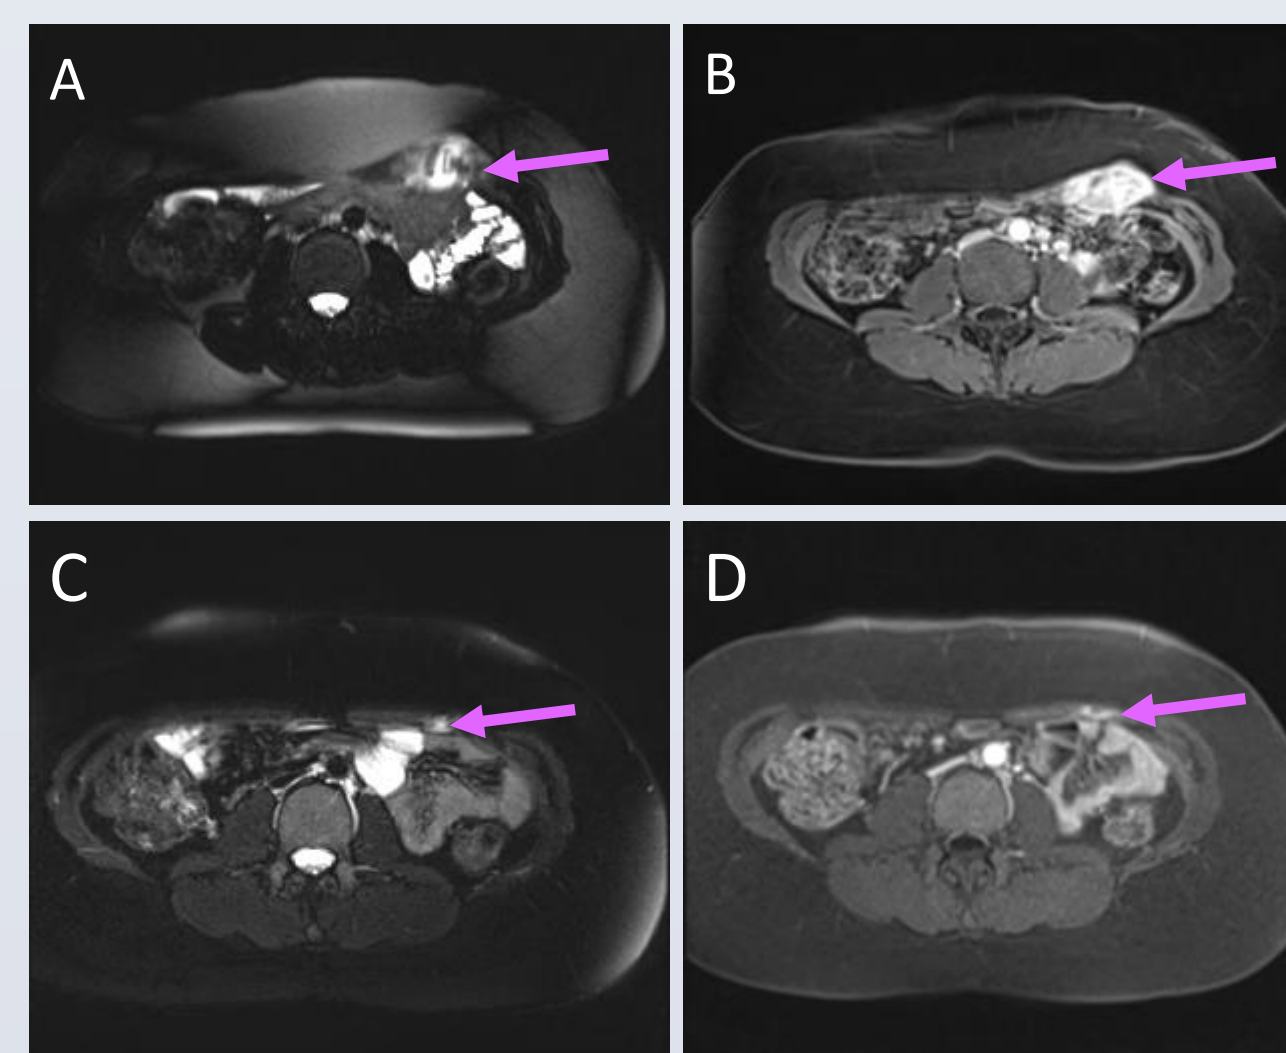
T2-fat-saturated (A) and T1-post-contrast (B) axial MR images of abdominal wall DF pre-treatment demonstrates high T2 signal and avid enhancement. Post treatment T2-fat-saturated and T1-post-contrast (C and D) showed decreased size and enhancement of DF.
